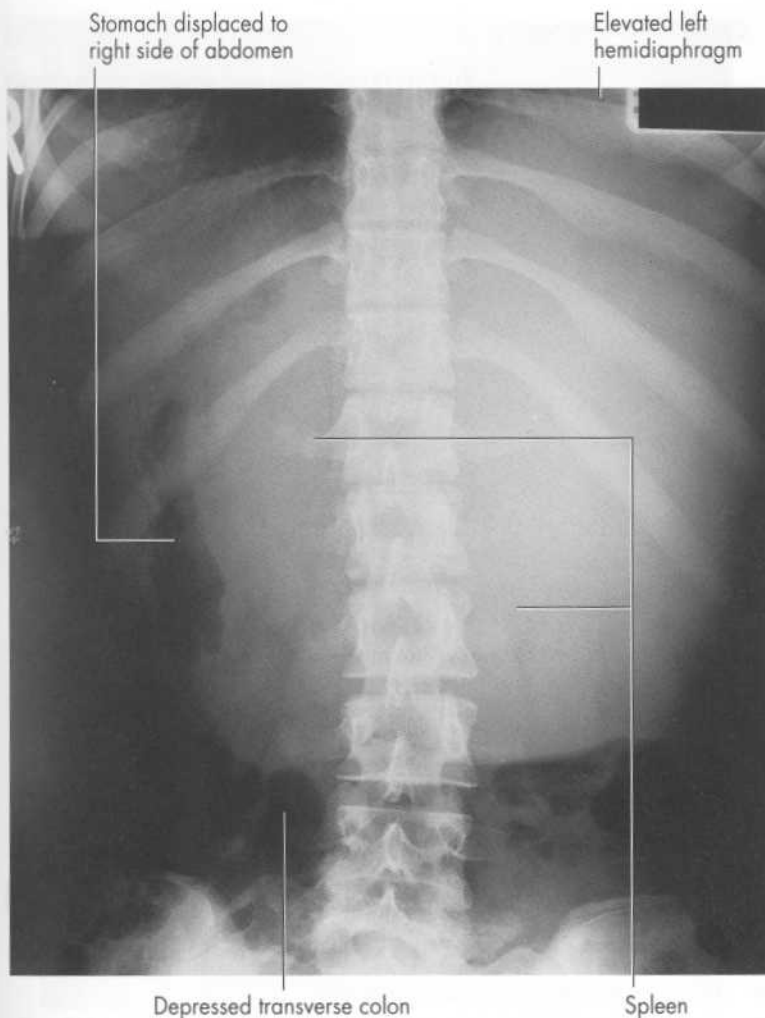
Splenomegaly This is the film of an adult female who presented with generalized ill health and a large mass in the left upper abdomen. Examination of the blood showed changes of leukaemia. The mass was shown on ultrasound to be a large spleen. The liver was not enlarged. Note the R marker just visible at the top left-hand corner of the film.
